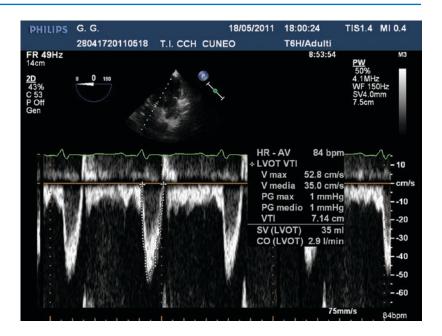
VTI assessment using PW Doppler spectrum. The sample is placed 5 mm below the plane of the aortic valve
